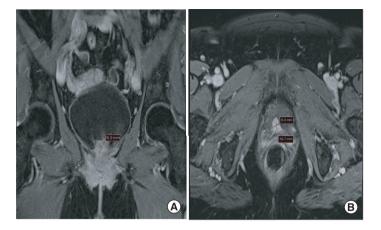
MRI pelvis (coronal and axial views) of nodular enhancing urinary bladder mass. (A & B) MRI pelvis (coronal and axial views) showing nodular enhancing soft tissue mass at the posterior segment of the urethra and urinary bladder base measuring $1.7 \times 1.5 \times 0.9$ cm compatible with the biopsy-proven malignant melanoma.
